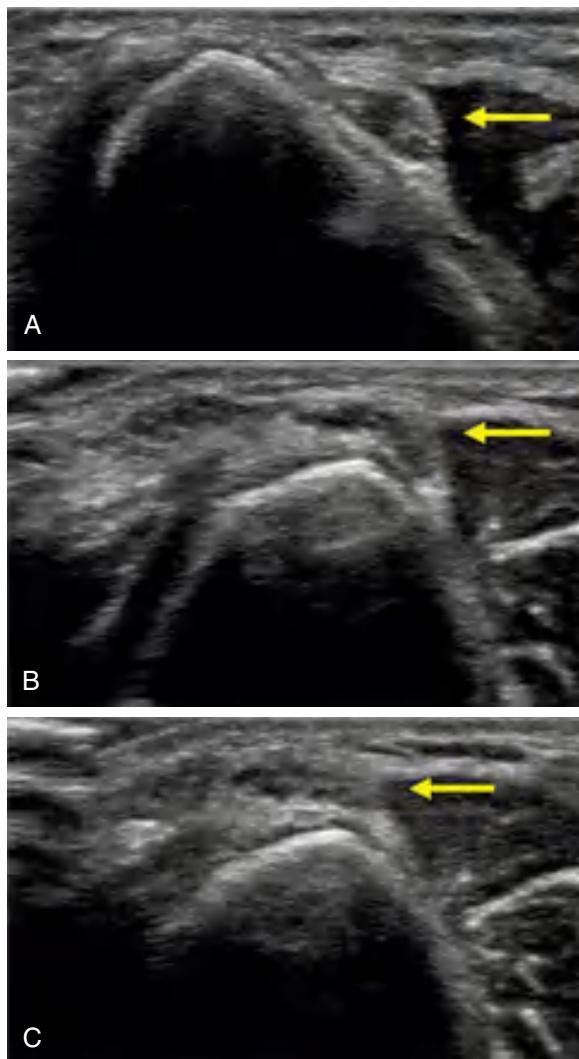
Ulnar nerve subluxation. Dynamic ultrasound imaging of the ulnar nerve (arrow) in the ulnar groove at the elbow. A, The ulnar nerve positioned appropriately in the ulnar groove with the elbow extended. With elbow flexion, (B) the nerve becomes perched upon the medial epicondyle. As the elbow moves into terminal flexion, (C) the nerve is completely dislocated anteriorly over the medial epicondyle. (Courtesy Nicholas Goyeneche, MD, ultrasound clinic files, Ochsner Clinic Medical Center.)
